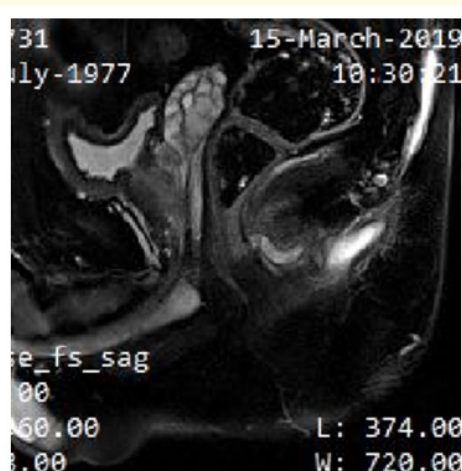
MRI 15/03/2019. MRI demonstrates a potential communication among the anal fistula and pilonidal sinus.
